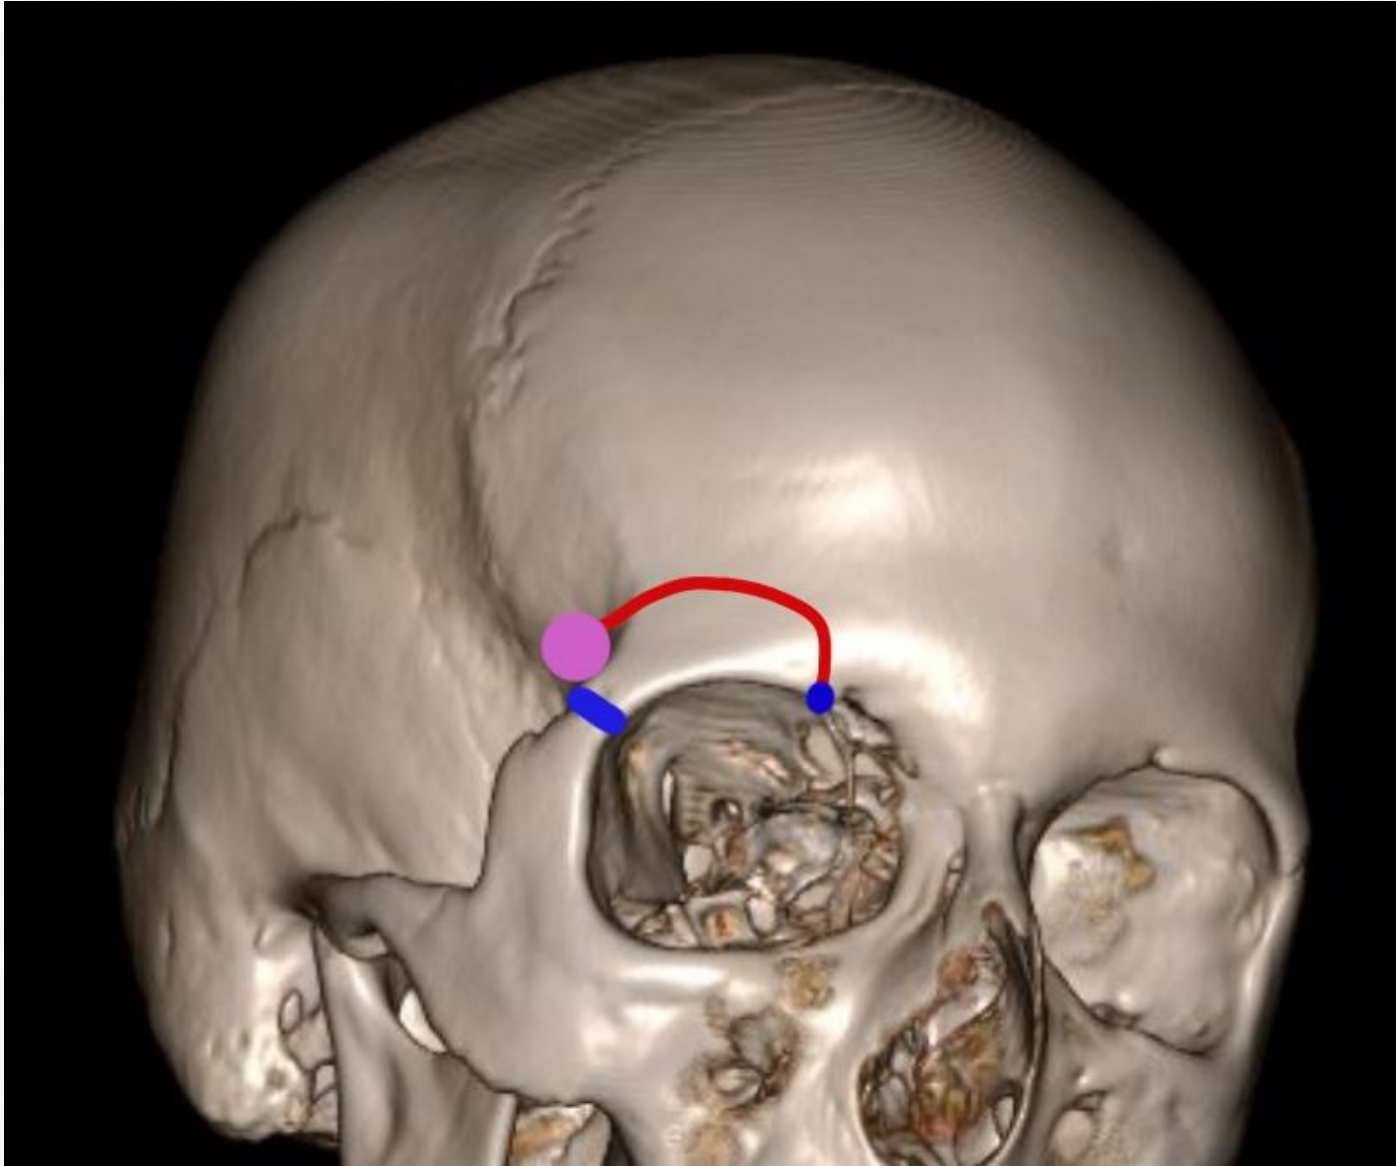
CT head 3D depicting surgical access for the mini orbitozygomatic craniotomy. McCarthy's point (purple) was burred open and the craniotome path (red) projects along the superior aspect of the eyebrow and towards the orbital rim with the supraorbital nerve as the medial border. The Sonopet apex knife (blue) was used through the frontozygomatic suture and at the supraorbital rim towards the anterior fossa floor. Osteotome trajectory not pictured.
